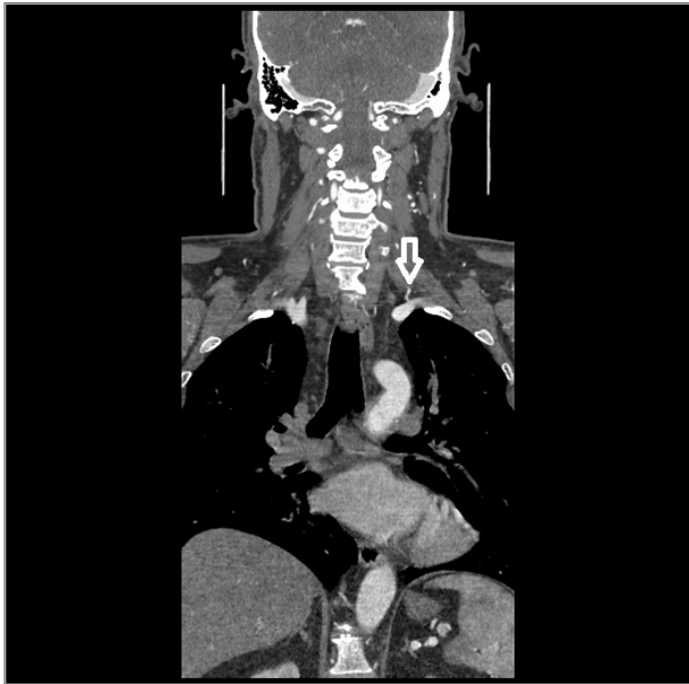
Computed tomography angiography of thorax, MPR reconstruction, frontal view - auto bypass from the medial aspect of the descending thoracic aorta supplying the left subclavian artery - black arrow.
